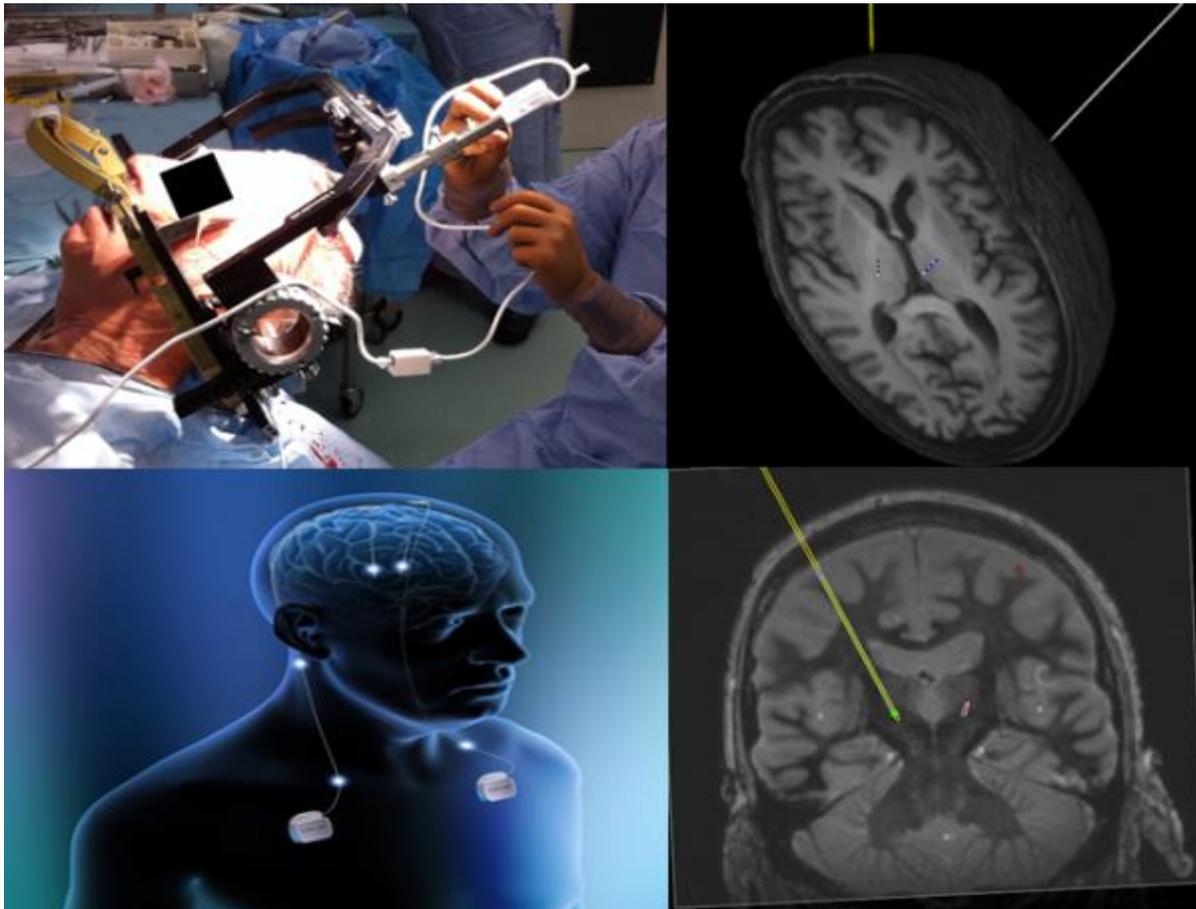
Deep Brain Stimulation involves stereotactic placement of brain electrodes using MRI to target. The electrodes are attached to subcutaneous pulse generators. Taken from (Green AL, 2020) with permission
